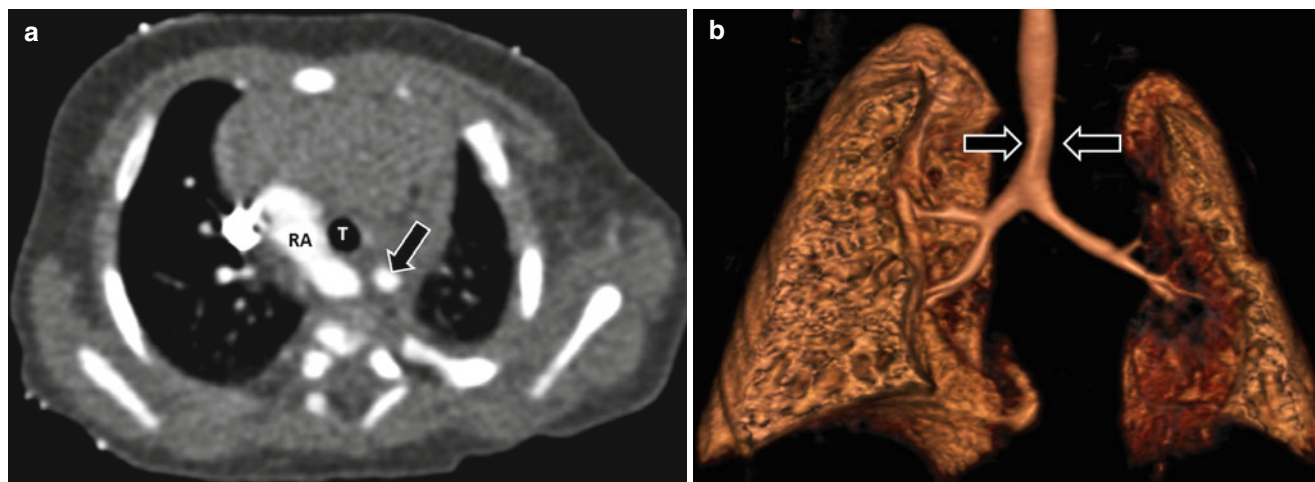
Right aortic arch with an aberrant left subclavian artery in a 2-month-old girl who presented with respiratory distress and dysphagia. (a) Enhanced axial CT image shows a right aortic arch (*RA*) with an
